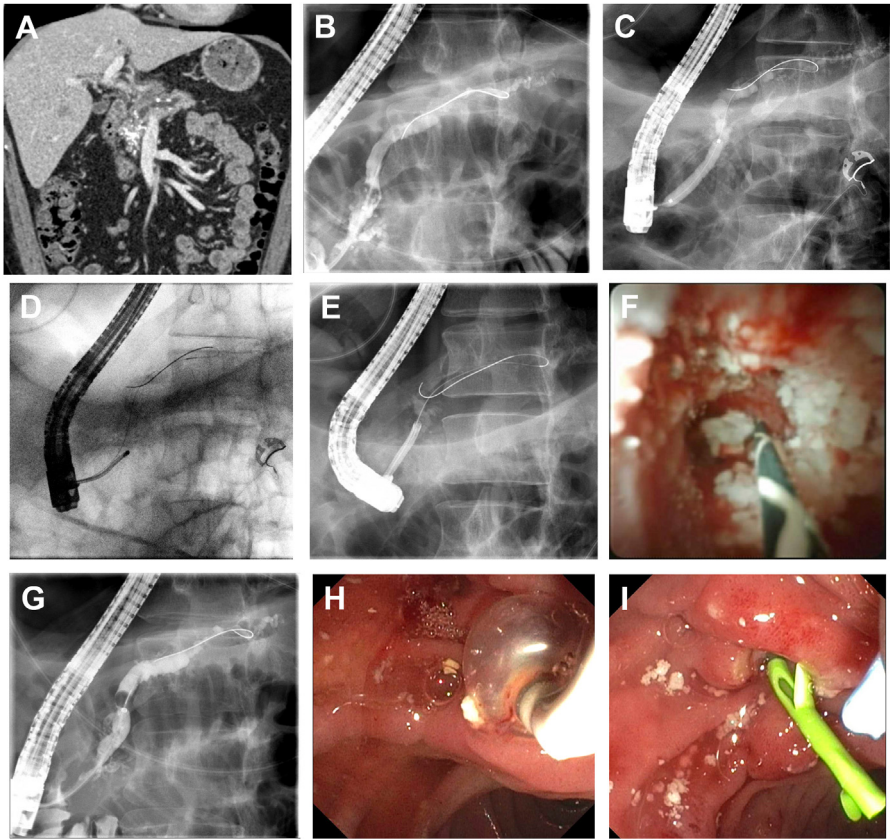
Endoscopic management of a patient with chronic calcifying pancreatitis after undergoing ESWL. (A) CT scan before ESWL demonstrating multiple large stones in the head of the pancreas. (B) After ESWL, contrast injection demonstrates multiple filling defects and a stricture in the head of the pancreas. (C) After a pancreatic sphincterotomy is performed, the stricture in the head of the pancreas is dilated. (D) Basket stone retrieval is attempted but unable to advance past the stones. (E) A pancreatoscope is passed into the main PD. (F) Stones are visualized and EHL is performed, yielding stone fragments. (G, H) An extraction balloon is used to remove stone fragments, fluoroscopic and endoscopic views, respectively. (I) A stent is placed in the PD to facilitate further drainage.
